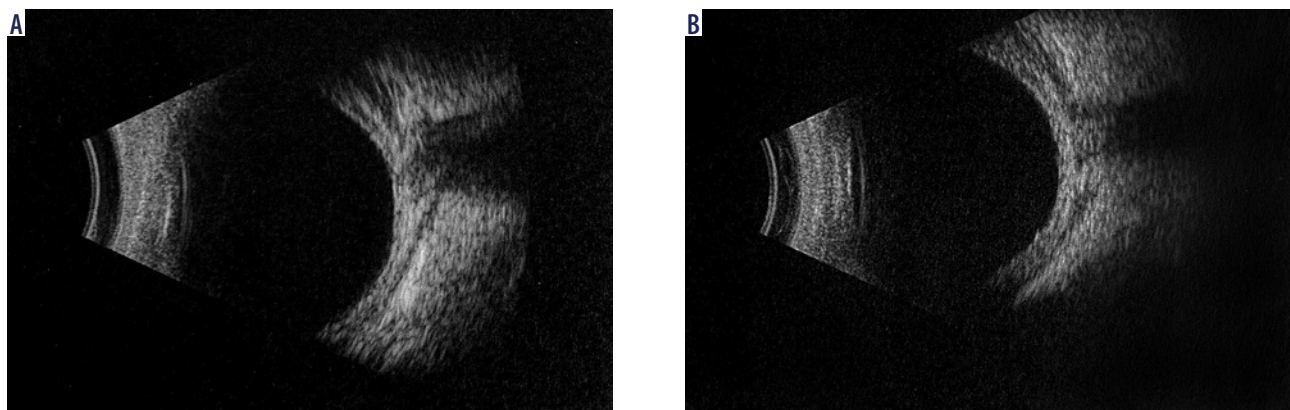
B-scan ultrasound: hypoechoic band under the tenon's capsule in both eyes (T-sign)
